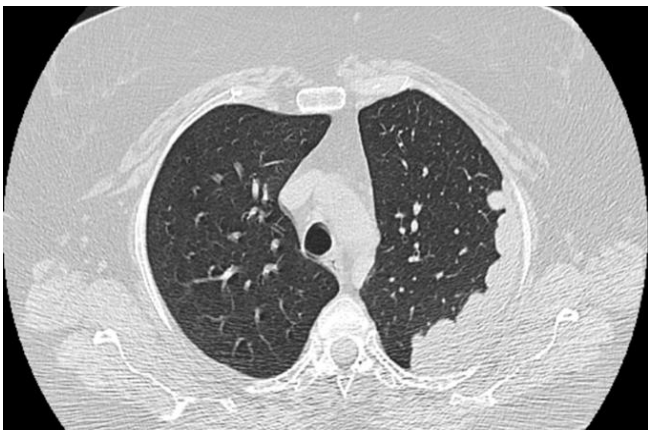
Thorax computed tomography, where extensive nodular thickening of the left peripheral pleura can be observed.
